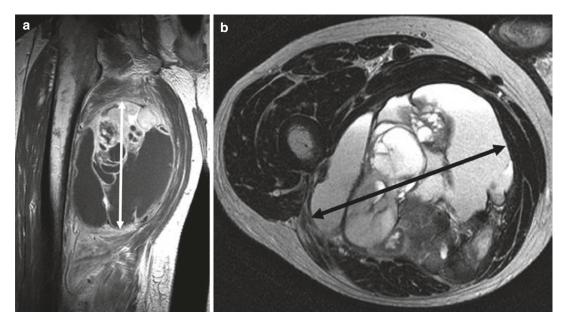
(a, b) T stage according to AJCC/UICC and MSTS. (a) Coronal contrast-enhanced T1-weighted SE and (b) axial T2-weighted TSE images of a patient with a pleomorphic sarcoma show a large tumor in the posterior compartment of the thigh. Tumor diameter is measured with exclusion of the pseudocapsule as demonstrated.
